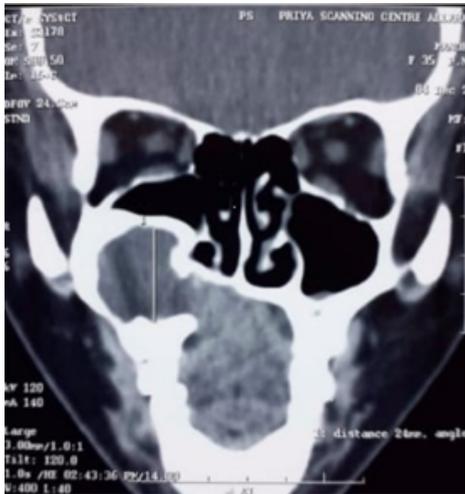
CT scan (coronal section) showing destruction of the right upper alveolar margin with lifting of floor of right maxillary antrum
